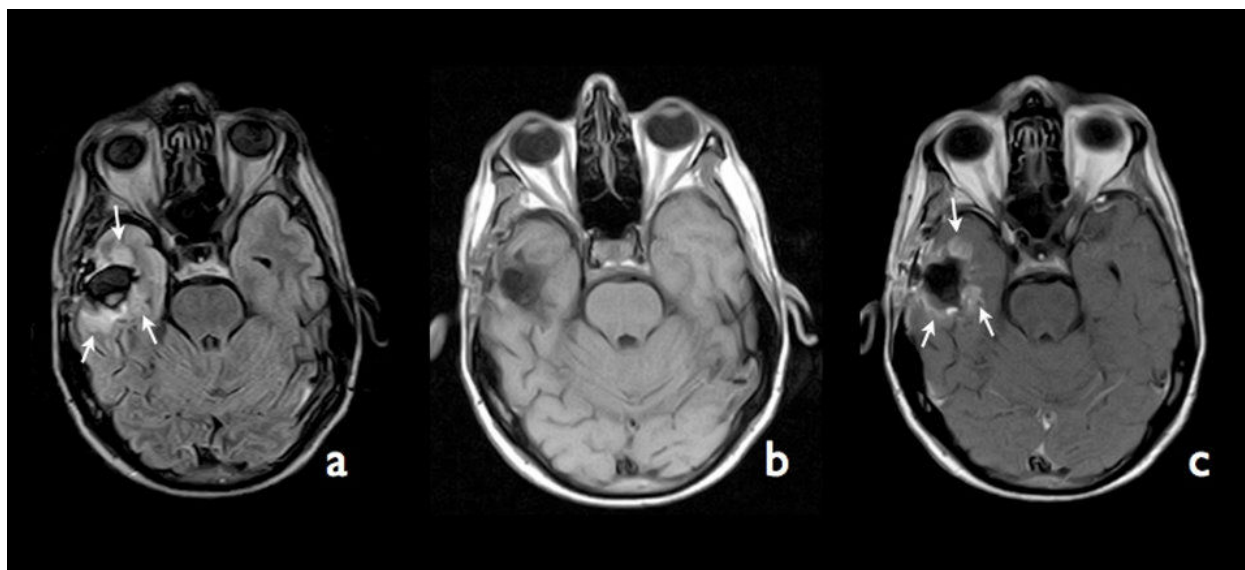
One year after initial surgery, FLAIR image (a) showed an irregular rim of increased signal (arrows) around the surgical cavity in the right temporal lobe. The lesions appeared iso- to low signal on T1WI (b) and nodular enhancements on post-contrast T1WI (c).
